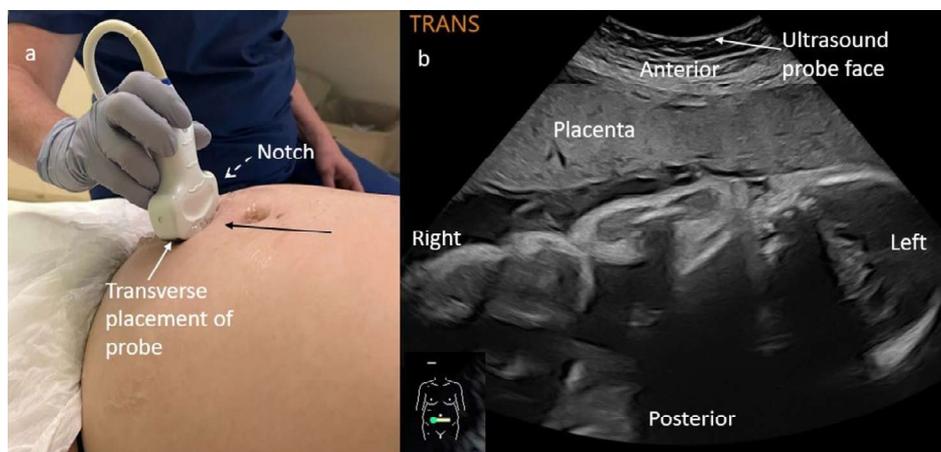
(a) Placement of the ultrasound probe on maternal abdomen when scanning in a transverse plane. Notch on probe side (dashed arrow) is positioned towards maternal right and operator, so orientation of ultrasound image is correct. (b) Ultrasound image demonstrating anatomical positions in a transverse plane, probe face with maternal skin line (arrow), and anterior placenta. Body marker indicates transverse plane.
